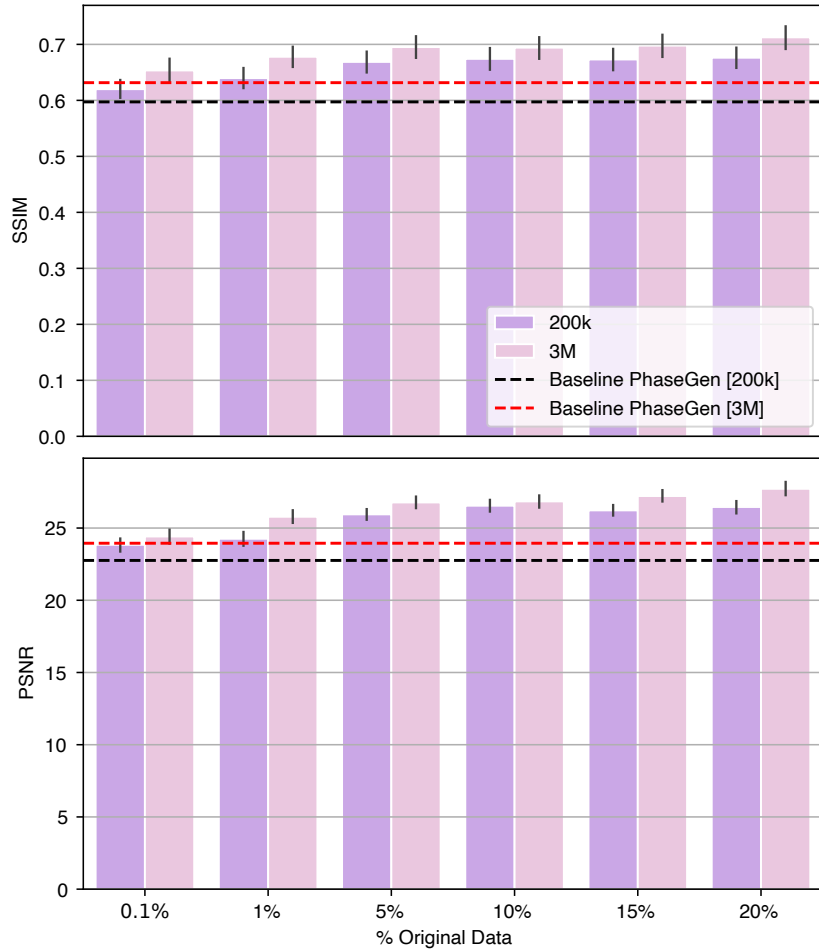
Results of the MRI reconstruction task with different ratios of real-phase data to synthetic-phase data by PhaseGen. Shown are the results for the following amounts of real-phase data: 0.1%, 1%, 5%, 10%, 15%, 20%. The experiment is conducted for the 200k and the 3M model at an undersampling rate of four. Figure published as is in [103].
